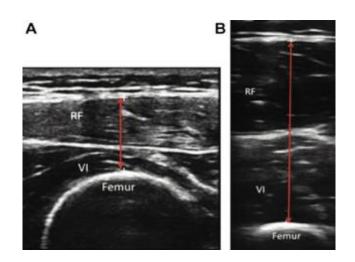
Thigh ultrasound demonstrating (A) maximal compression and (B) minimal compression<sup>\*</sup>. Muscle thickness is indicated by the red arrow. RF, rectus femoris; VI, vastus intermedius.
